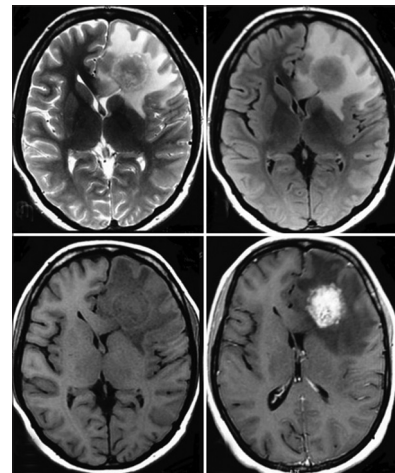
Plain and contrast magnetic resonance images shows rounded mass lesion with central and peripheral hypointensity on T2 weighted images in left frontal region showing moderate enhancement with surrounding edema and mass effect
